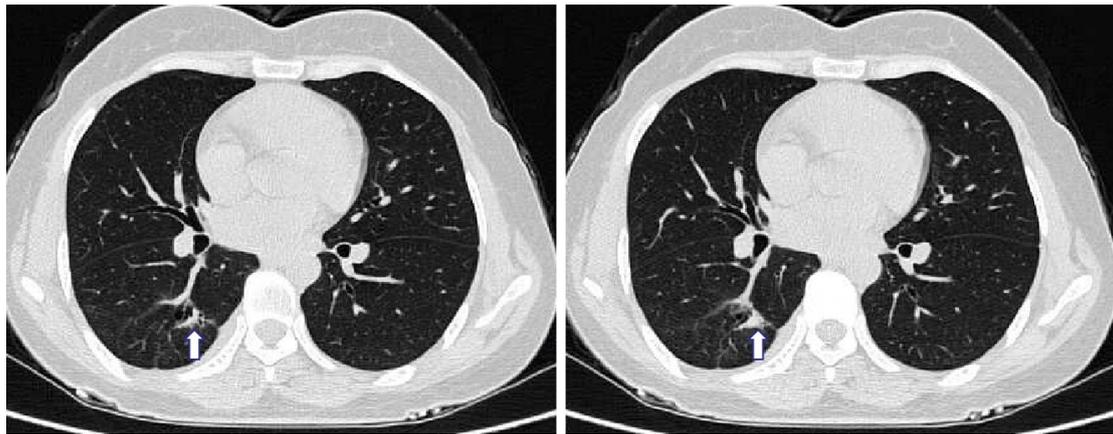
After multiple chemotherapy, chest CT was re-examined on 24 June 2019. The area indicated by the arrow shows that the lesion of the right lower lobe was significantly reduced and the thick wall disappeared.
